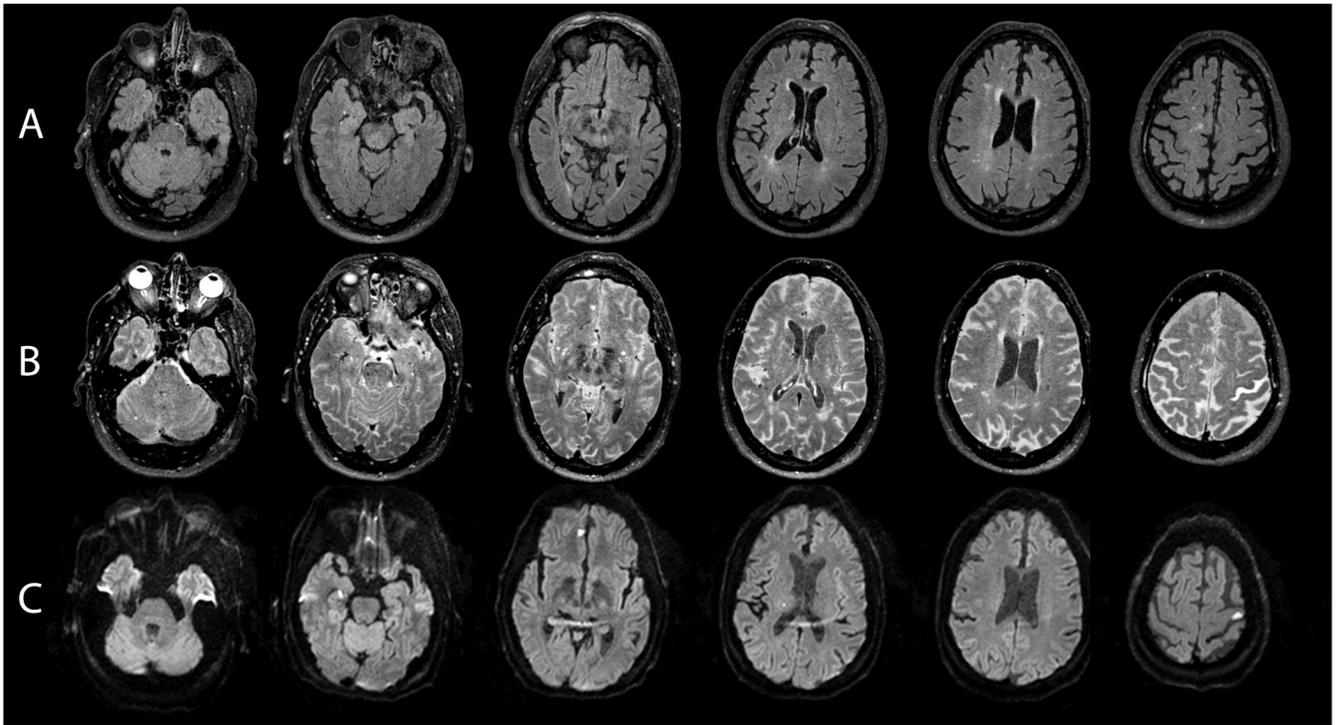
Generalized HARM 74-year old man who underwent off-pump CABG. A. Baseline FLAIR obtained before surgery. B. Post-gadolinium scan. Gadolinium was administered 20 hours after surgery, and a 3T MRI was done 20 hours later. Post-gadolinium FLAIR shows enhancement throughout the subarachnoid space (severe sulcal and background HARM). The CSF in the ventricles appears gray (mild/moderate ventricular HARM). Gadolinium enhancement is also seen in the eye. C. DWI obtained after surgery. Patient had 4 DWI lesions.
